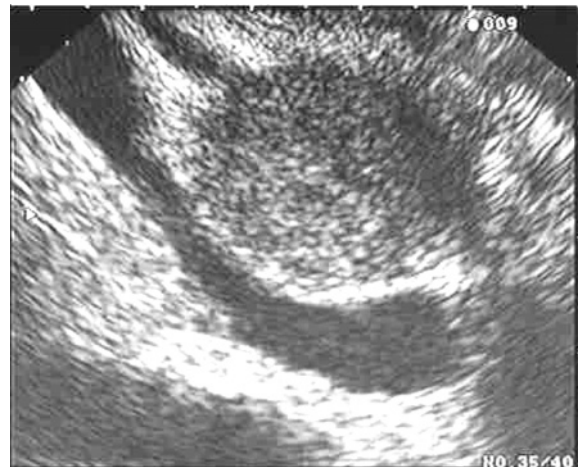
Venous compression. In this case, a large mass was seen on CT and MRI, both of which demonstrated portal vein narrowing and suggested unresectability (without venous reconstruction). Although EUS confirmed a large mass, there was an intact hyperechoic tissue plane between the mass and portal vein in all views, suggesting a lack of venous adherence. The lesion was successfully resected without venous reconstruction.
